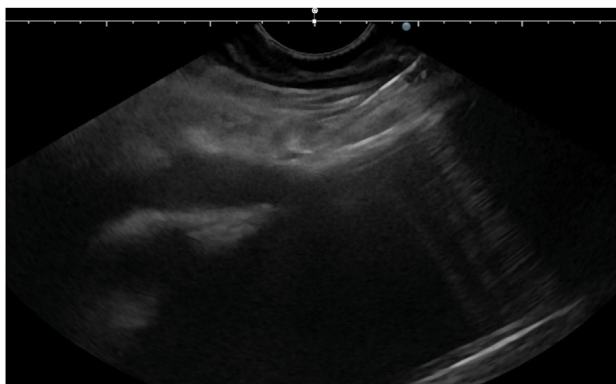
Endoscopic ultrasound image during endoscopic ultrasound-guided coeliac plexus neurolysis. The needle tip is at the origin of the coeliac trunk, prior to instillation of local anaesthetic and absolute alcohol.
